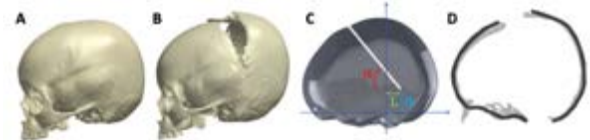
(A) Preoperative, (B) Postoperative CT models, (C) FE model with osteotomy and parameters, (D) comparison of end-of-expansion FE model (dark grey) and postoperative CT model (light grey).
